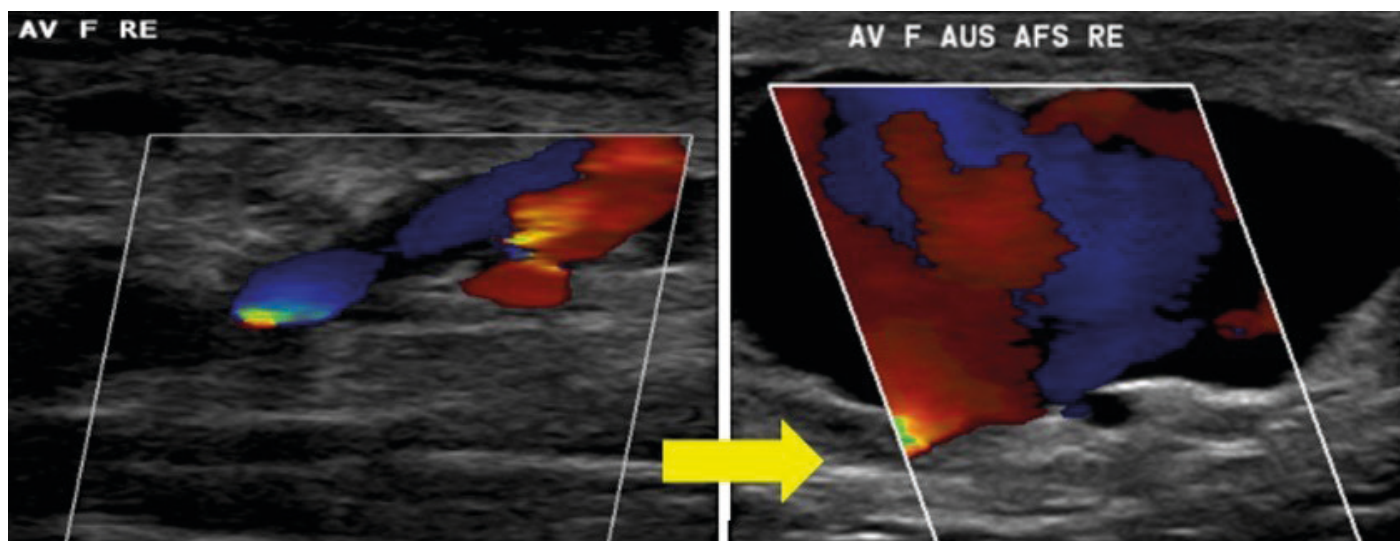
Figure A-141. Duplex sonographic examination of the degenerated arteriovenous fistula.
